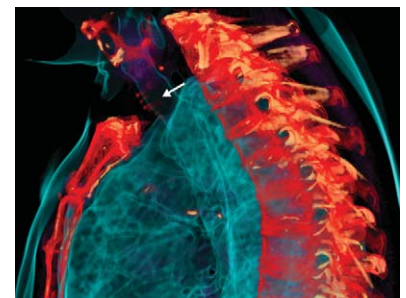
CT-generated 3D reconstruction images show multiple calcified cartilaginous nodules of the tracheal wall (arrows) with sparing of posterior wall.
